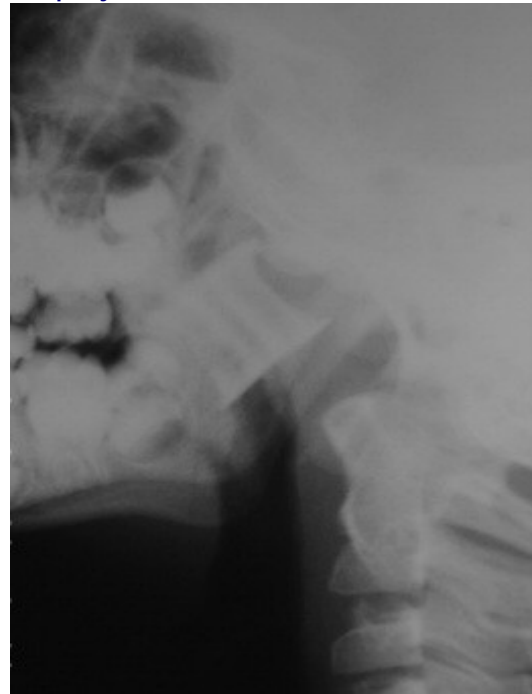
Lateral plain radiograph of neck showing a foreign body in nasopharynx
